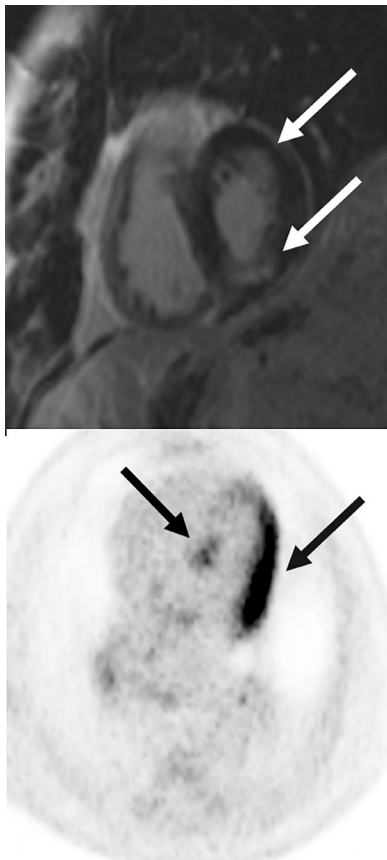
Characteristic Imaging of CS Patients. (A) Cardiac magnetic resonance imaging. Short axis slice at the basal level showing midmyocardial inferior scar and anterolateral midmyocardial and subendocardial scar (blue arrows). (B) PET imaging. Short axis slice at the basal level showing FDG uptake in the lateral wall and septum (blue arrows). CS = Cardiac sarcoidosis; PET = positron emission tomography; FDG = 18-fluorodeoxyglucose.
